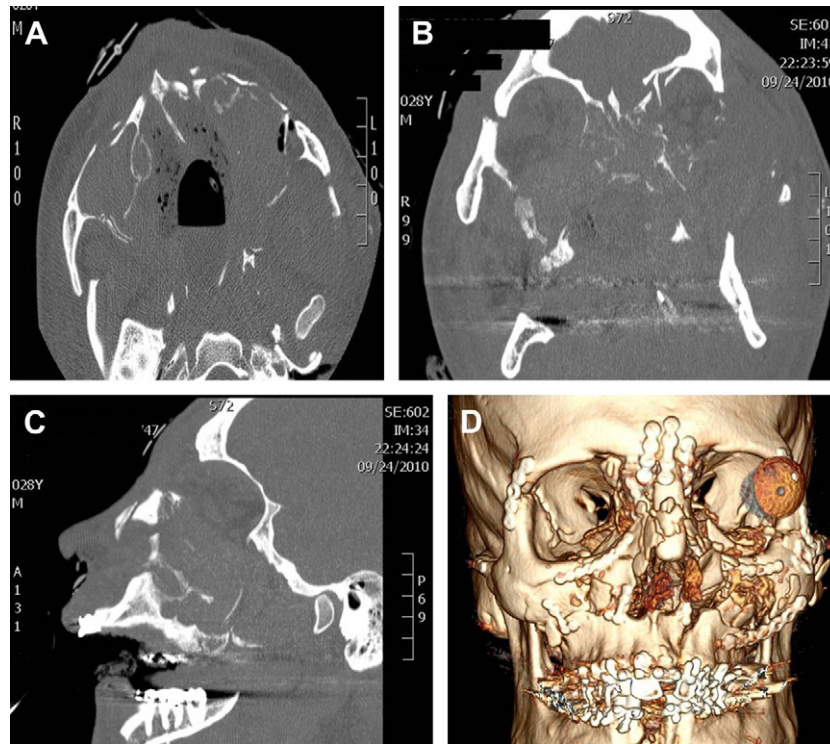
CT scan of comminuted midface fracture. (A) Axial slice, (B) coronal slice. (C) sagittal slice, and (D) 3D reconstruction after surgical repair.
